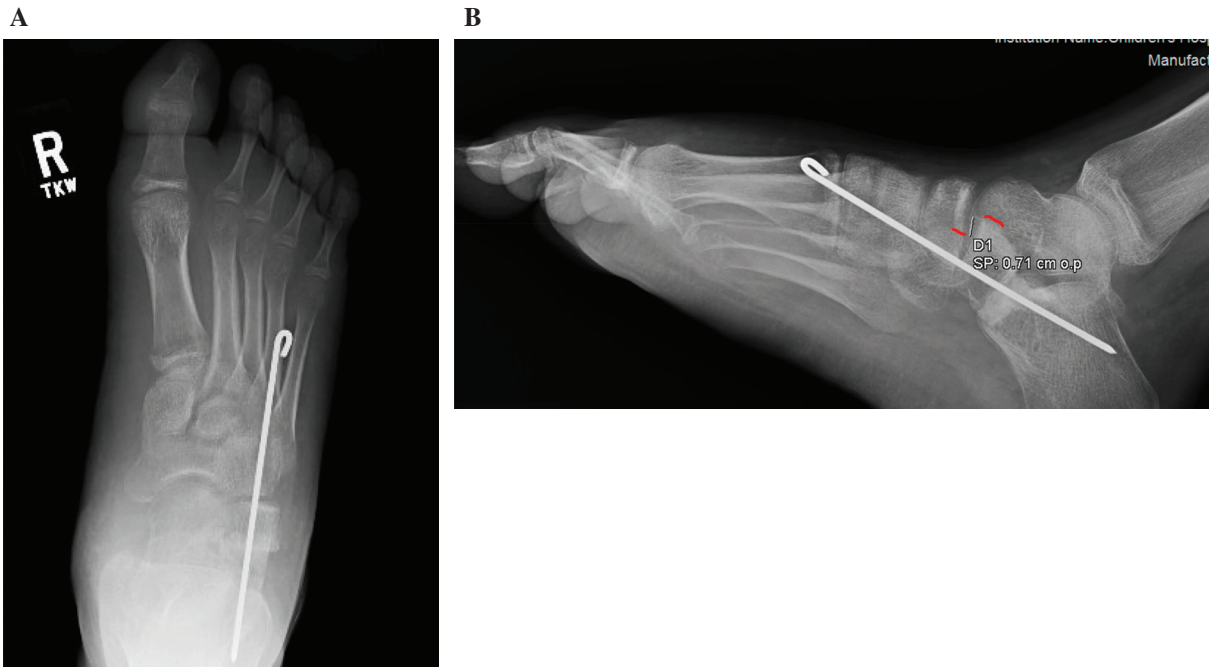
(A) AP and (B) lateral 6-week postoperative radiographs demonstrating persistent CC joint subluxation.
